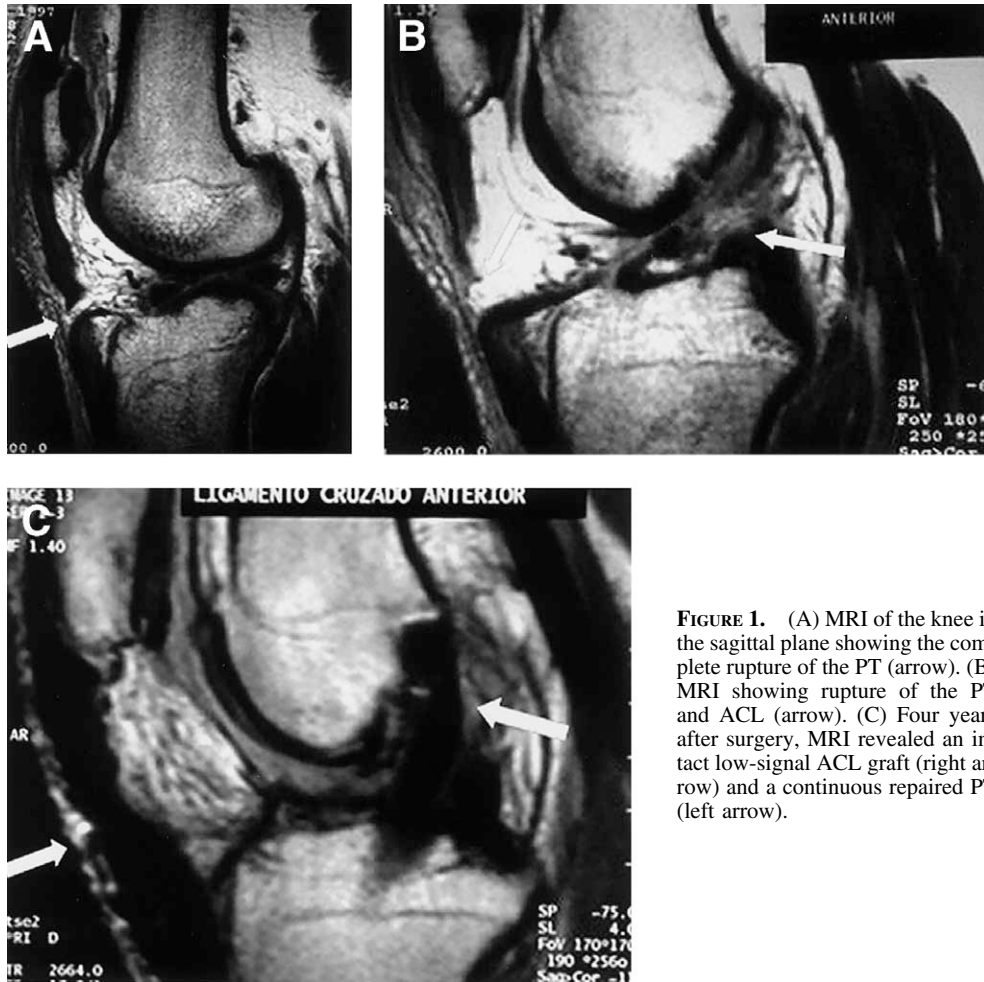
(A) MRI of the knee in the sagittal plane showing the complete rupture of the PT (arrow). (B) MRI showing rupture of the PT and ACL (arrow). (C) Four years after surgery, MRI revealed an intact low-signal ACL graft (right arrow) and a continuous repaired PT (left arrow).
